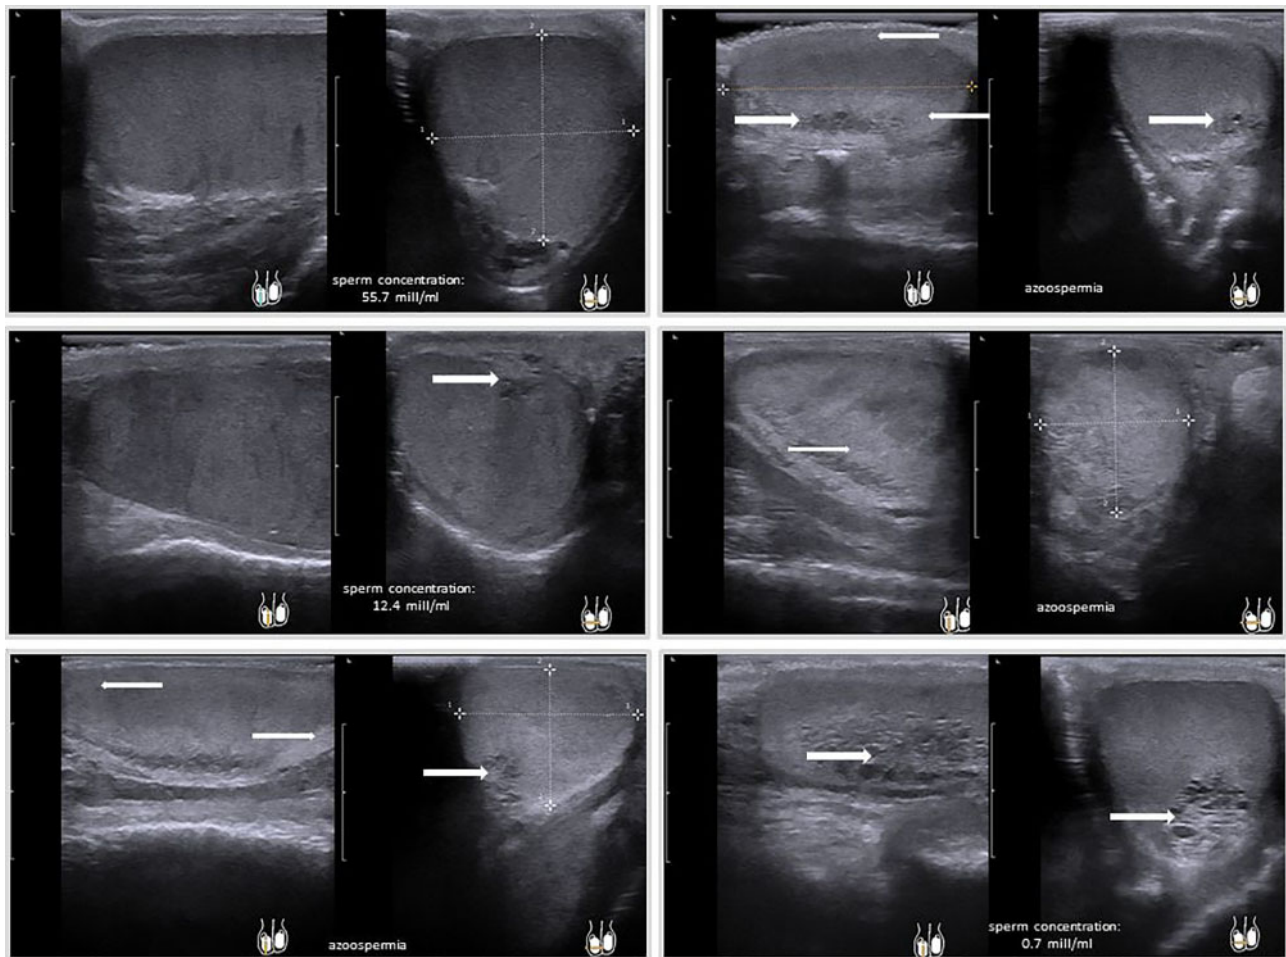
Testicular ultrasound imaging of selected males with infantile nephropathic cystinosis, variably showing dilation of the rete testis (thick arrows). A hyperechogenic rim in the peripheral regions of testicular parenchyma (thin arrows) is seen in patients without sperm in their semen.
